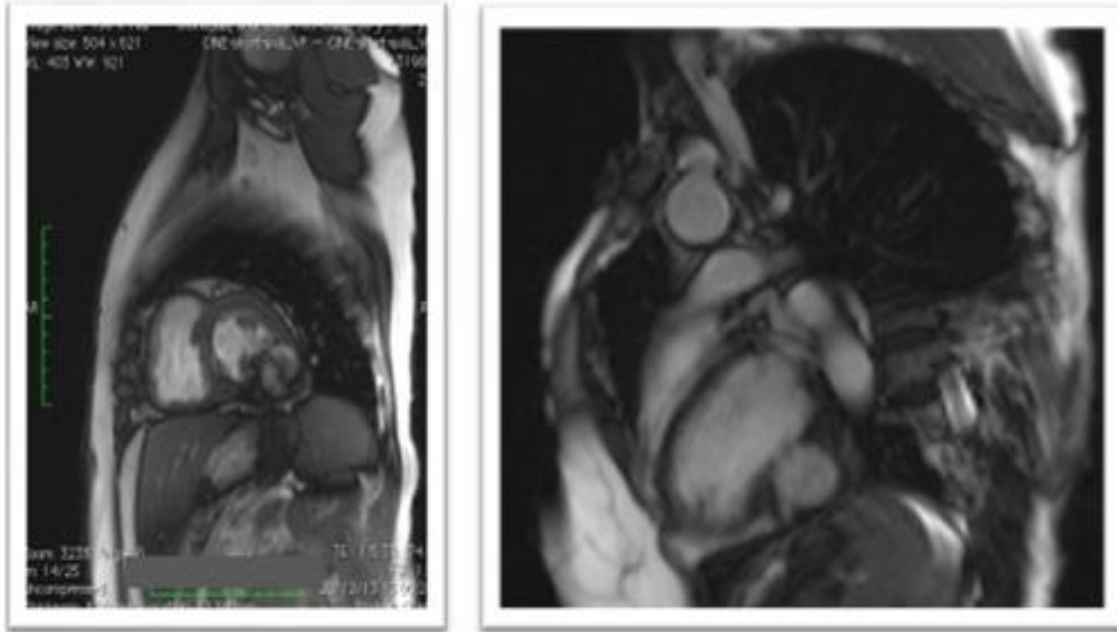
A, B. MRI images of a patient admitted for an infero-basal infarction. Presence of a pseudo aneurysm secondary to a rupture of the inferior wall with a small neck of 12 mm and a significant blood stasis.
